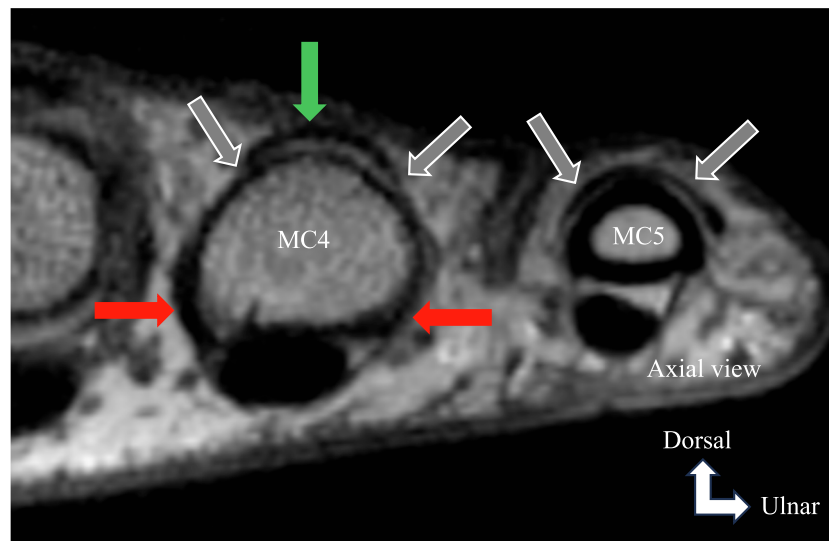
Axial proton density (PD)-weighted MRI of the MCPJ of the fourth and fifth fingers showing transverse fibers (gray arrows) originating from the interosseous tendons (red arrows) and extending to the extensor tendon (green arrow).
